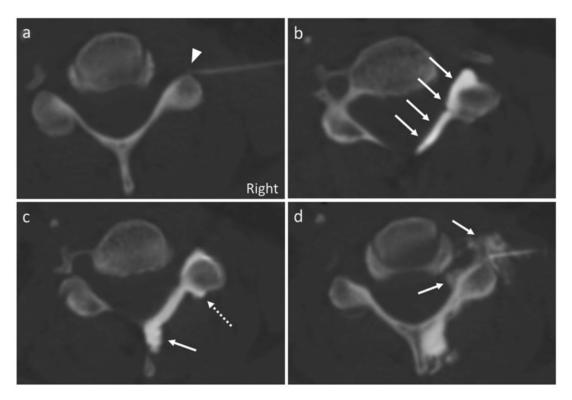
Patient 2. CT-guided right C4–C5 transforaminal epidural steroid injection in a 48-year-old female with right C5 radiculopathy. Precontrast axial image (a) shows the needle tip in the posterolateral right C4–C5 neural foramen (arrowhead). After injection of dilute iohexol 300 mgl/mL, contrast appears to be within the dorsal epidural space (b, arrows). However, a more inferior image shows that contrast is actually within the retrodural space of Okada extending posterior to the ligamentum flavum into the interspinous region (c, solid arrow) and partially filling the right C5–C6 facet (dashed arrow). The needle tip was repositioned, and subsequent contrast injection shows central and peripheral epidural flow (d, arrows).
